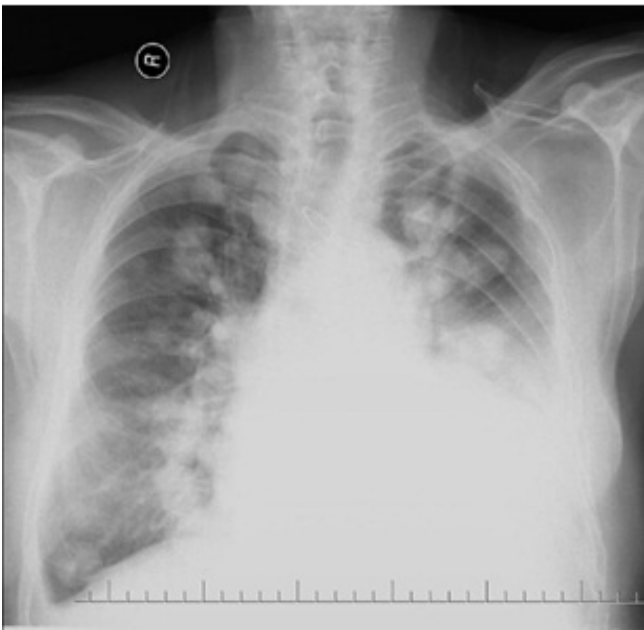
Case no 4: chondrosarcoma of the first finger of the hand. Multiple calcific metastatic lesions are seen in the chest x-rays on the application of 17th month postoperatively.
